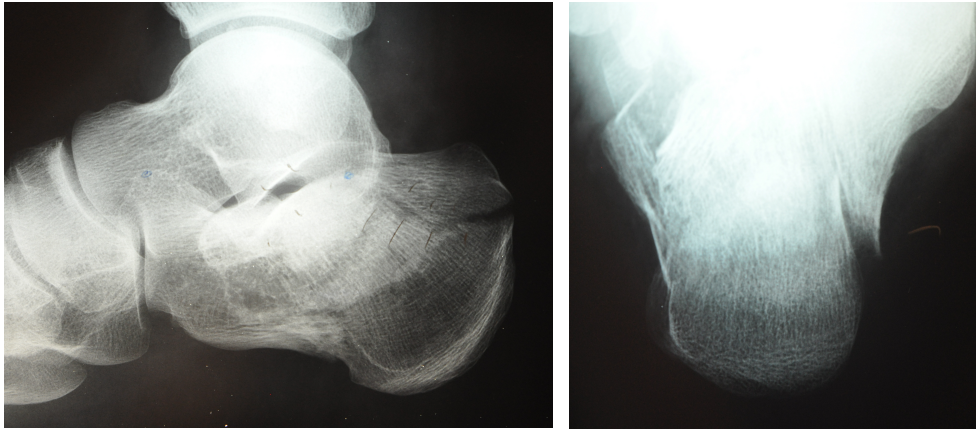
Lateral and Axial Plan X-rays of fractured calcaneus
